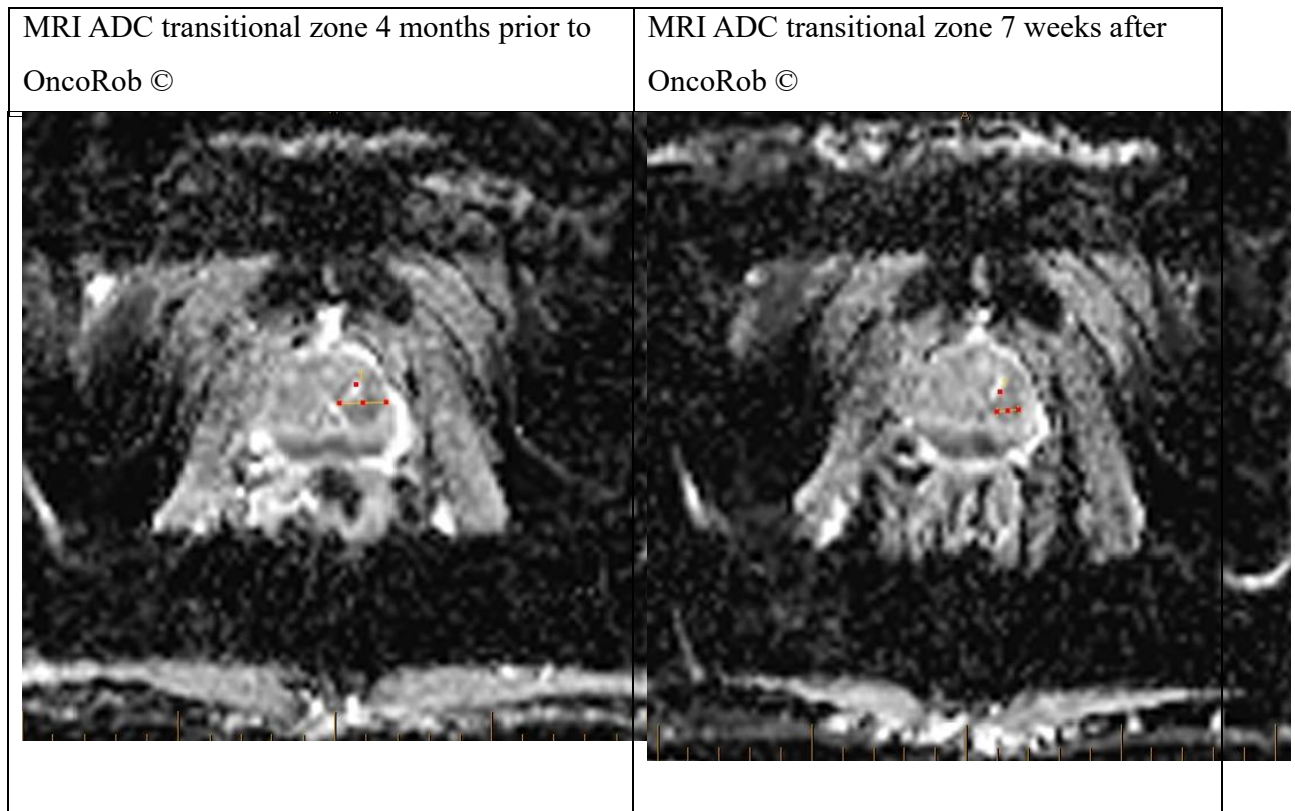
Prostate Cancer Patient’s MRI (Magnetic Resonance Imaging) Images Pre and Post OncoRob © Treatment
